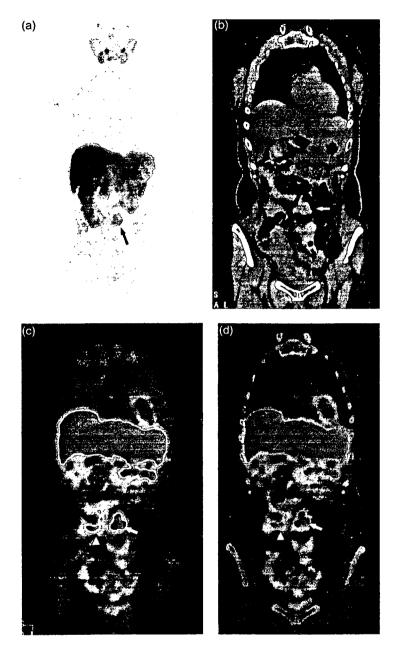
(a) MIP image of [C-11] choline positron emission tomography. Abnormal uptake of [C-11] choline is observed in the middle of the abdomen (arrow). There is no significant physiological uptake in the colon. (b-d) Coronal computed tomography (b), coronal positron emission tomography (c), coronal co-registered positron emission tomography/computed tomography hybrid image (d). Thickening in the wall of the sigmoid colon is observed in the computed tomography (b, arrow). Abnormal uptake of [C-11] choline is observed in the sigmoid colon corresponding to the wall thickening (c, d, arrow). Differentiation between physiological uptake in the small intestine (c, d, arrow head) and tumor uptake can be made by fused PET/CT images. PET, positron emission tomography; CT, computed tomography.
